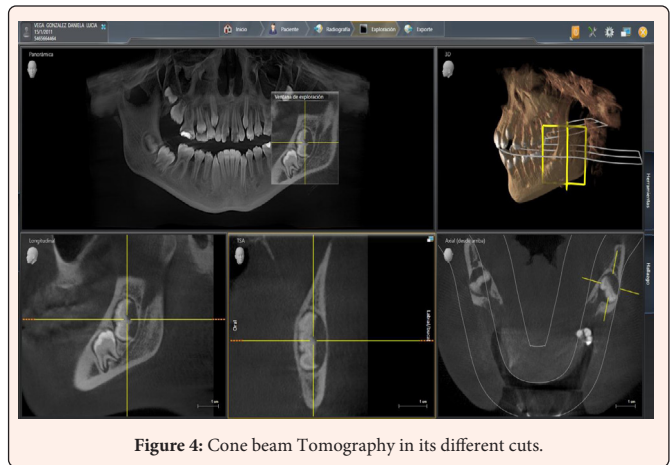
Cone beam Tomography in its different cuts.
